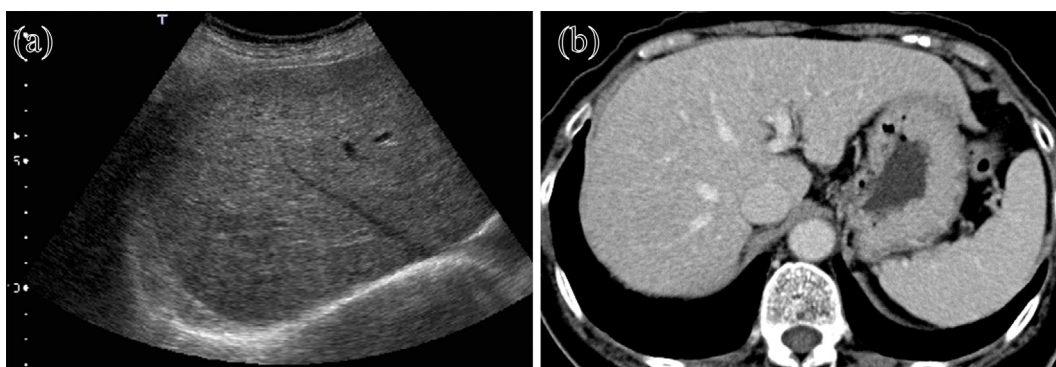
(a) Abdominal ultrasonography revealed an irregular liver surface, coarse liver parenchyma, and multiple intrahepatic diffuse small nodules. (b) Abdominal contrast-enhanced computed tomography showed chronic liver damage, mild left hepatic lobe swelling, and splenomegaly.
